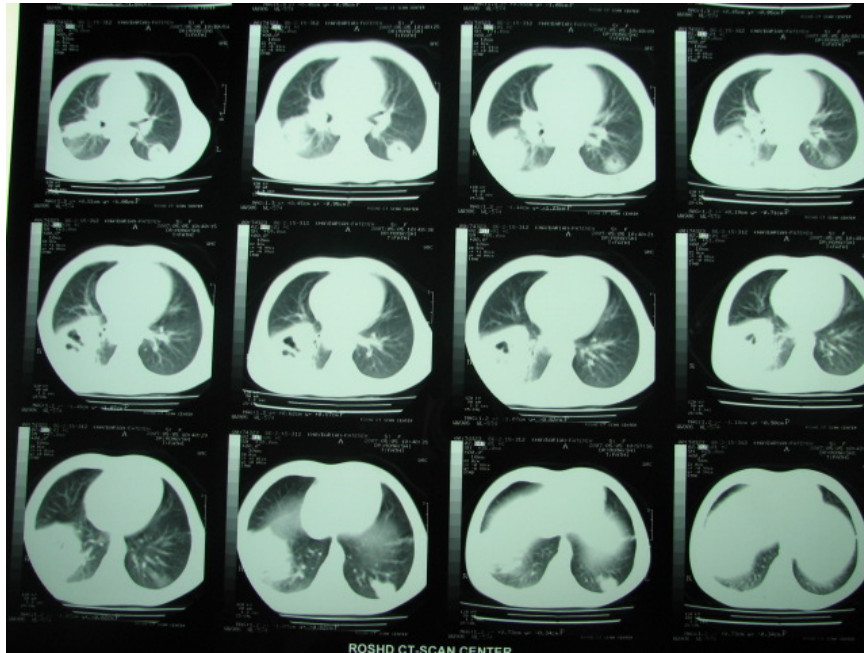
Chest CT Scan of the patient
